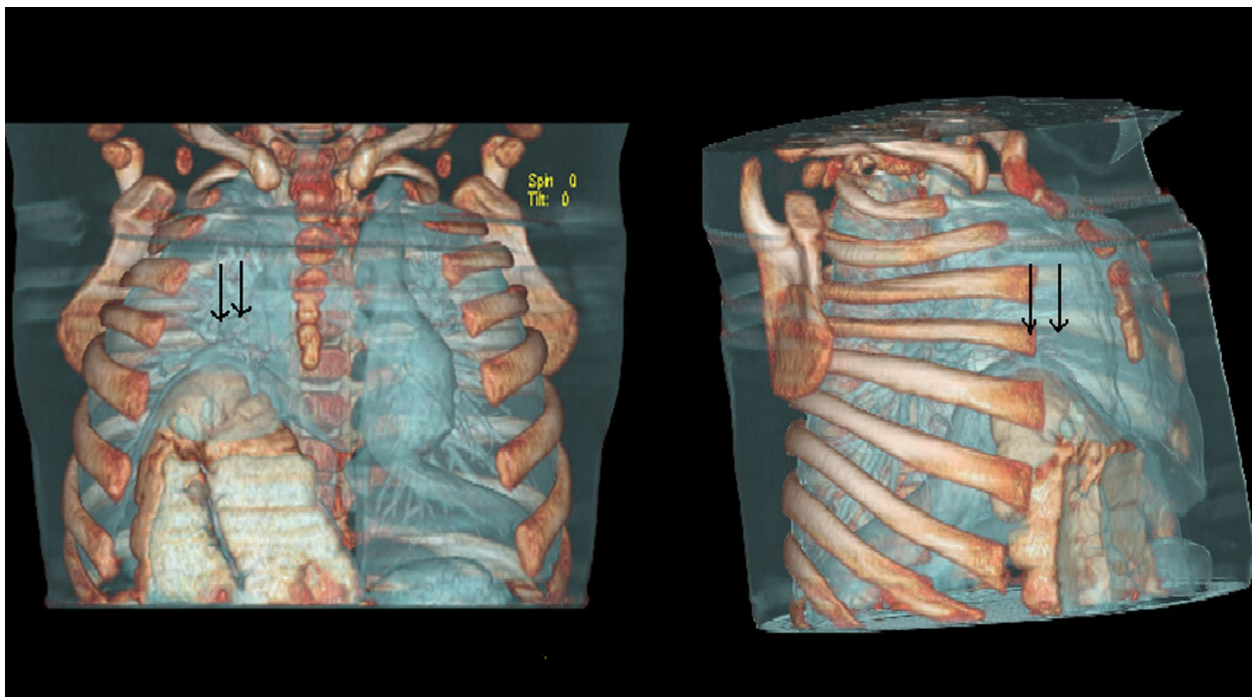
Coronal three-dimensional reconstruction of contrast-enhanced computed tomography demonstrates colonic loop with its mesenteric fat and vessels ascending along the right anterior perihepatic space (arrows). Right hemidiaphragm is elevated; no sign of defect is present
